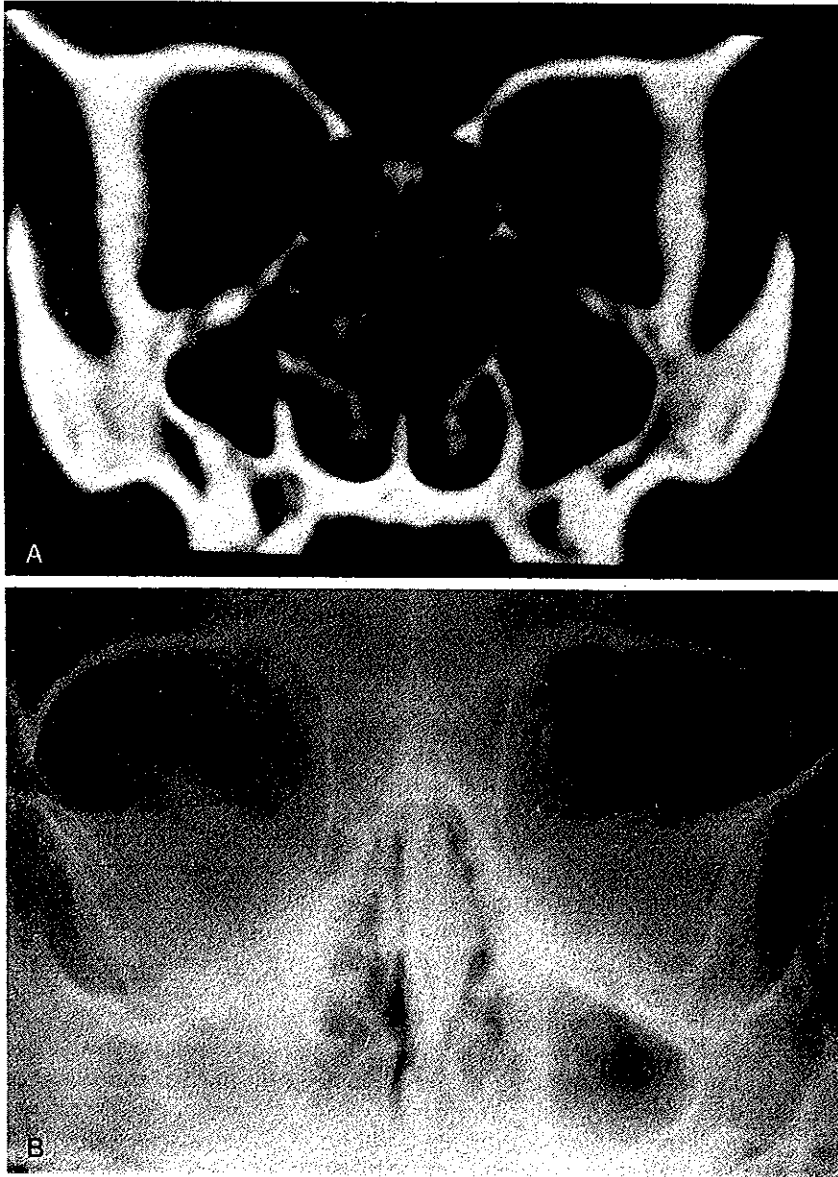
Comparison of plain film and CT scan of the same patient taken on the same day. *A*, Plain Waters radiograph showing what appears to be near total opacification of the ethmoid and right maxillary sinuses, and *B*, the coronal CT scan showing relatively minor disease around the osteomeatal complex.
